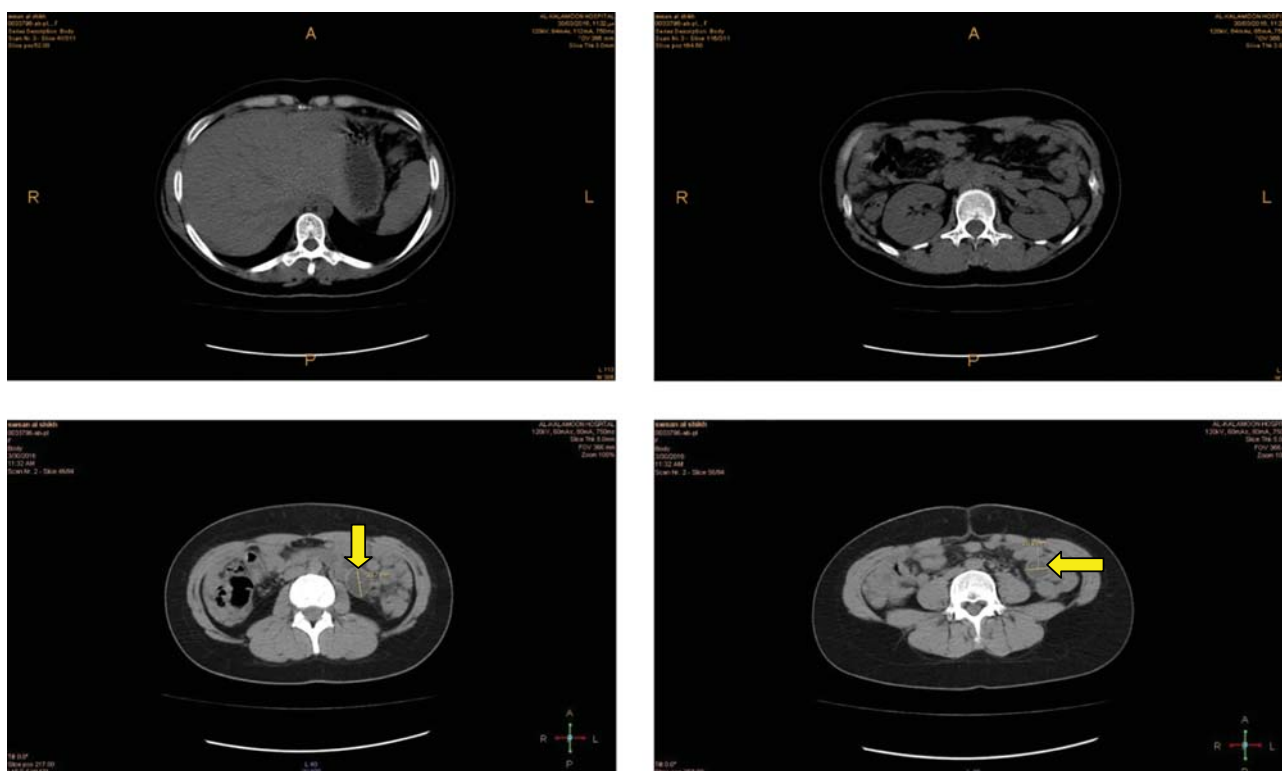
CT scan of the abdomen and pelvis after treatment. Images indicate very good improvement with no ascites and only two small cysts present in the abdomen. The yellow arrows indicate pelvic cysts.
